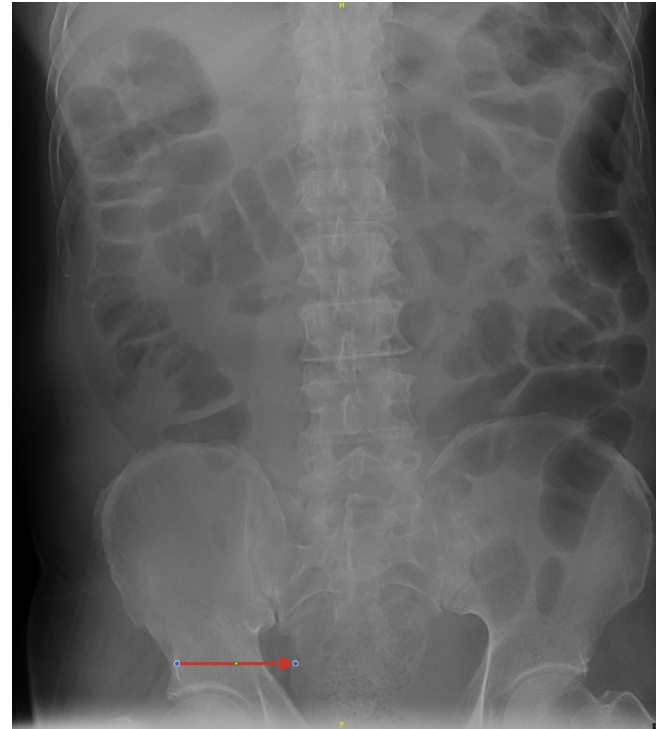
Abdominal Xray. Red arrow pointing towards faecoloma.
